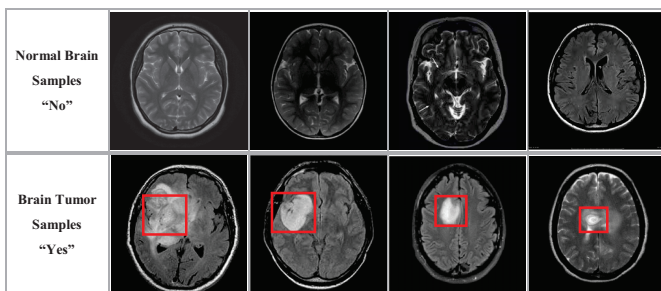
The samples of brain MRI images for different classes.
